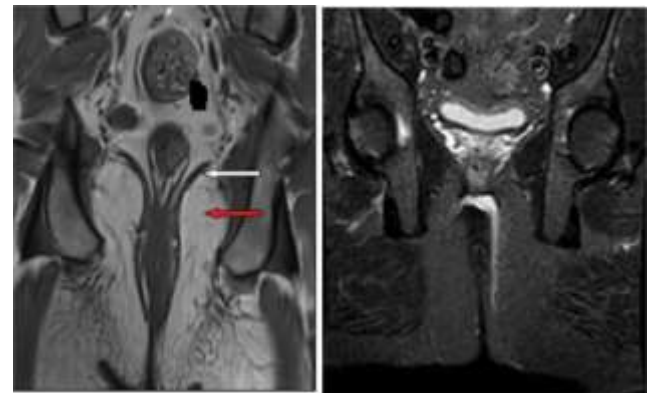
This image demonstrates that the levatorani muscle (white arrow), the ischioanal fossa (red arrow), and the ischioanal fossa (blue arrow) are better visualized on coronal T1-weighted sequences.
